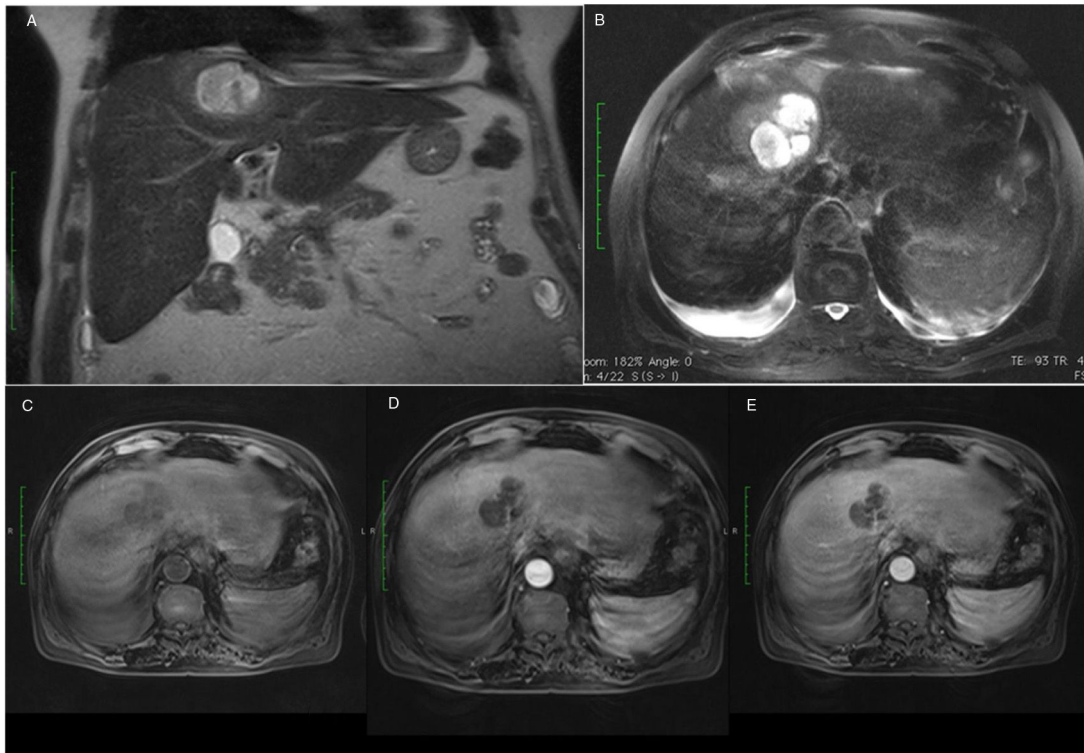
Abdominal MRI (A) Coronal plan, T2 HASTE sequences – nodular lesion in the IV/VIII segments of the liver (B) Axial plan, T2 FS weighted sequences – hypersignal with fluid and internal septae (C) before gadolinium injection (non-enhancement phase) (D) after gadolinium injection, arterial phase – without contrast enhancement (E) after gadolinium injection, portal phase- peripheral contrast enhancement of the lesion.
